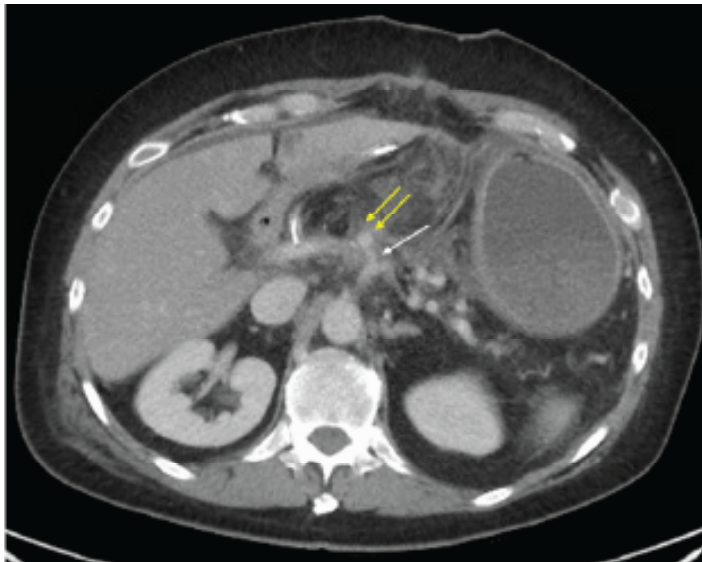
Axial computed tomography image with late arterial phase demonstrates a pseudoaneurysm (double yellow arrow) originating from the common hepatic artery (single white arrow). There is regional fat stranding related to pancreaticoduodenectomy complicated by post-pancreatectomy pancreatitis.
